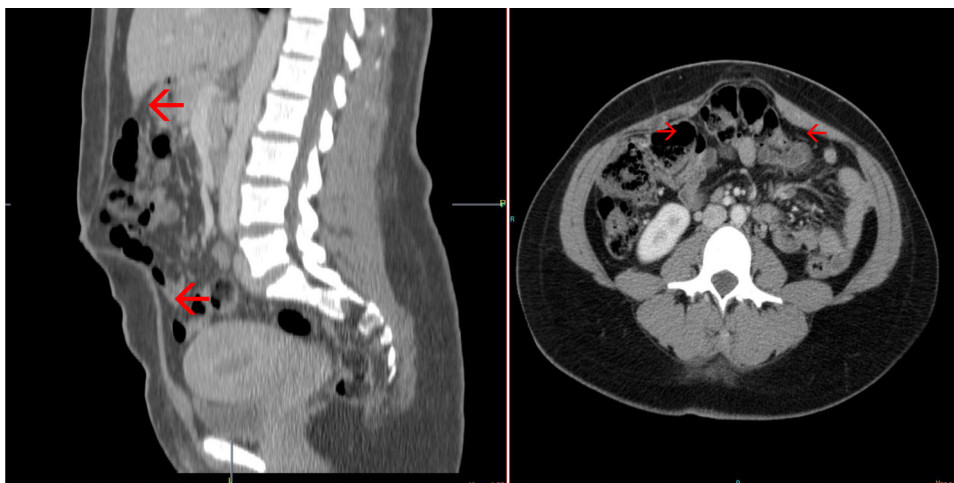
CT scan abdomen showing hernia with divarication. Arrows shows approximate dimensions.
